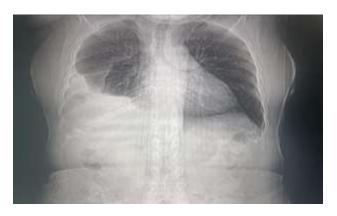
Chest radiography showing right sided pleural effusion.
